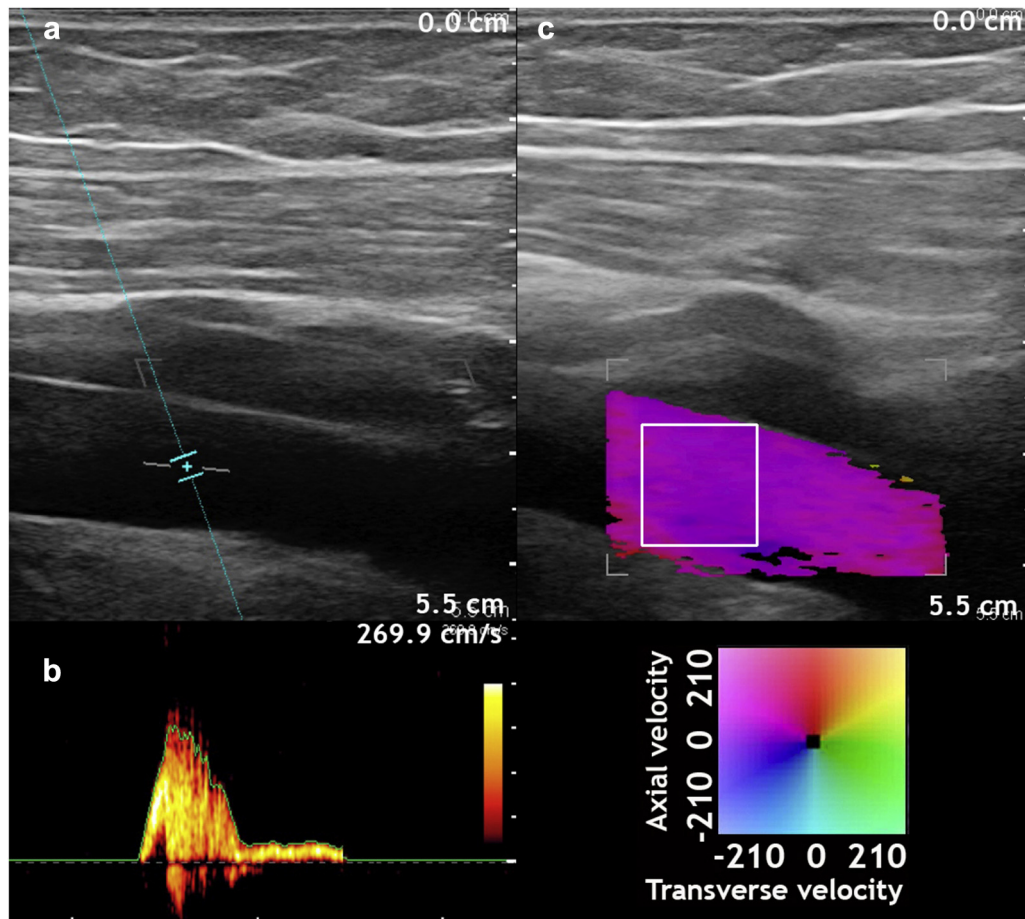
(a) Longitudinal scan of the femoral vein with conventional spectral Doppler ultrasound (SDUS). A range gate is placed centrally in the vessel and the angle correction is applied. The SDUS spectrogram (b) visualizes spectral data over time. Peak velocity is calculated by reading the highest point of the flow pulse spectral curve and comparing it with the velocity axis of the spectrogram in a professional quality vector graphics editor. (c) Longitudinal scan of the same femoral vein with vector flow imaging (VFI) estimation of the venous flow pulse. The videos were extracted from the scanner and analyzed in the editor in MATLAB. The *white box* outlines the region of interest. The color map in the lower right corner indicates flow direction and magnitude. The superimposed arrows are optional with VFI. In this study, no arrows were shown on the vector maps of the videos extracted for velocity estimation.
